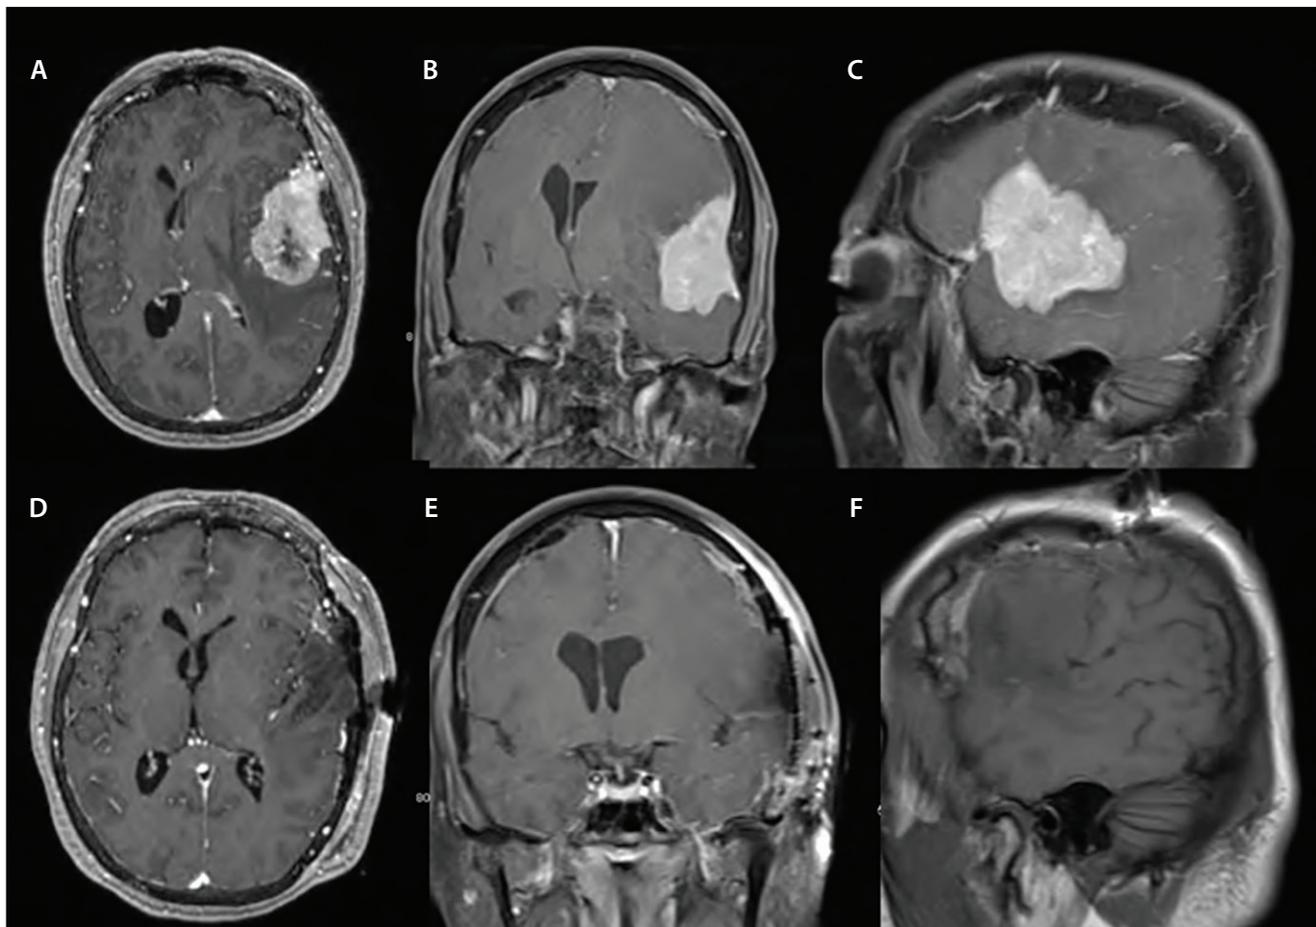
Representative images from preoperative and postoperative brain MRI. The top row shows a large dural based lesion, in axial (A), coronal (B), and sagittal (C) orientation that seems to be splitting the fissure between the frontal and temporal lobes. The bottom row (D-F) is the post-operative MRI that confirms gross total resection of this lesion, with preservation of adjacent brain.
